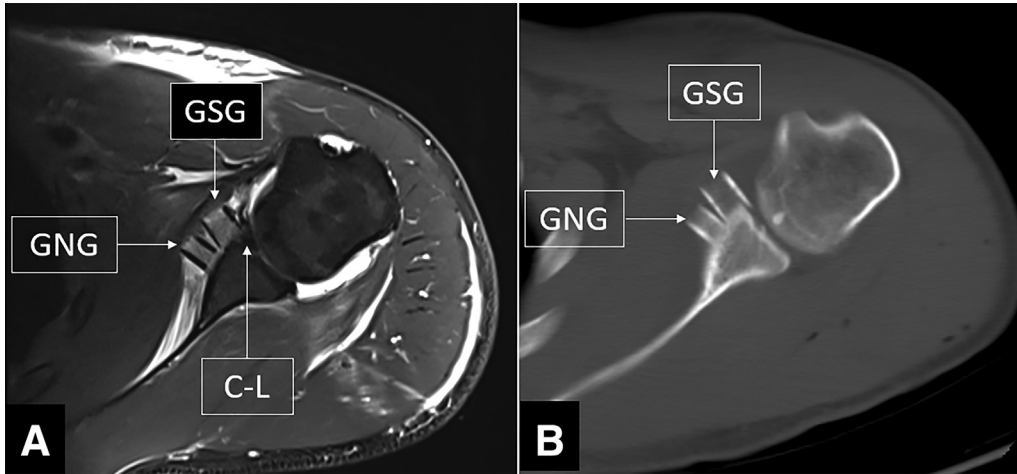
Postoperative transverse view of MRI (A) and CT (B) after glenoid bone grafting. Left shoulder. The glenoid-surface graft is placed at the same level of the cartilage surface of the glenoid (A) instead of the bony surface of the glenoid (B). Abbreviations: C-L, the reattached capsule labrum; CT, computed tomography; GNG, glenoid-neck graft. GSG, glenoid-surface graft; MRI, magnetic resonance imaging.
